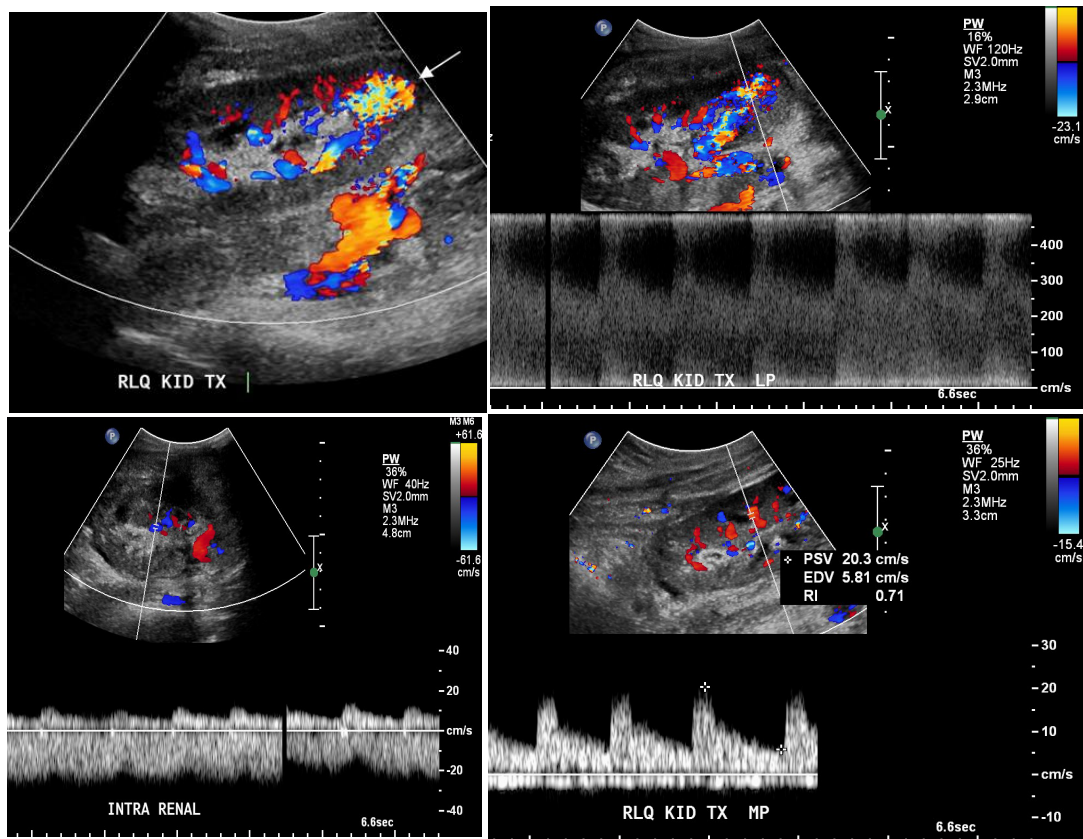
Arteriovenous fistula at the lower pole in the area of previous biopsy. (A) is a color Doppler image through the transplant kidney that shows color aliasing and turbulence at the lower pole suggestive of high velocity (arrow). (B), spectral waveform through the lower pole artery shows very high velocity (up to 400 cm/s) with increased diastolic flow. (C), spectral waveform through a mid pole vein shows slightly pulsatile waveform due to AV fistula. (D), through a mid pole vessel shows normal arterial velocity and wave form.
